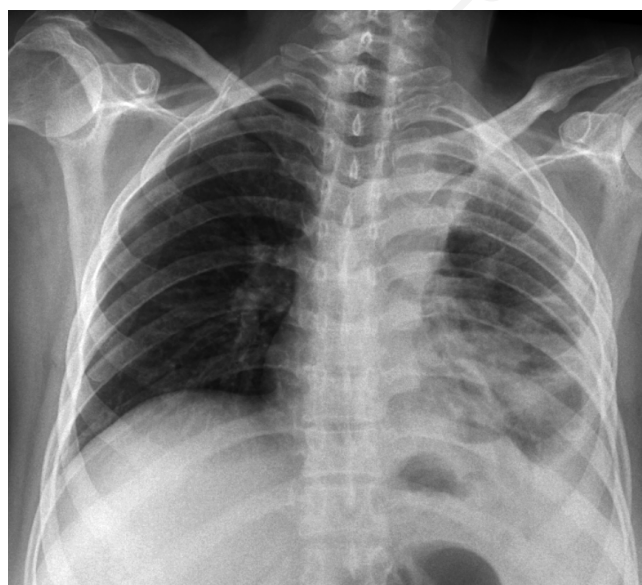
Chest roentgenogram showing improvement in pleural effusion post intrapleural streptokinase.
